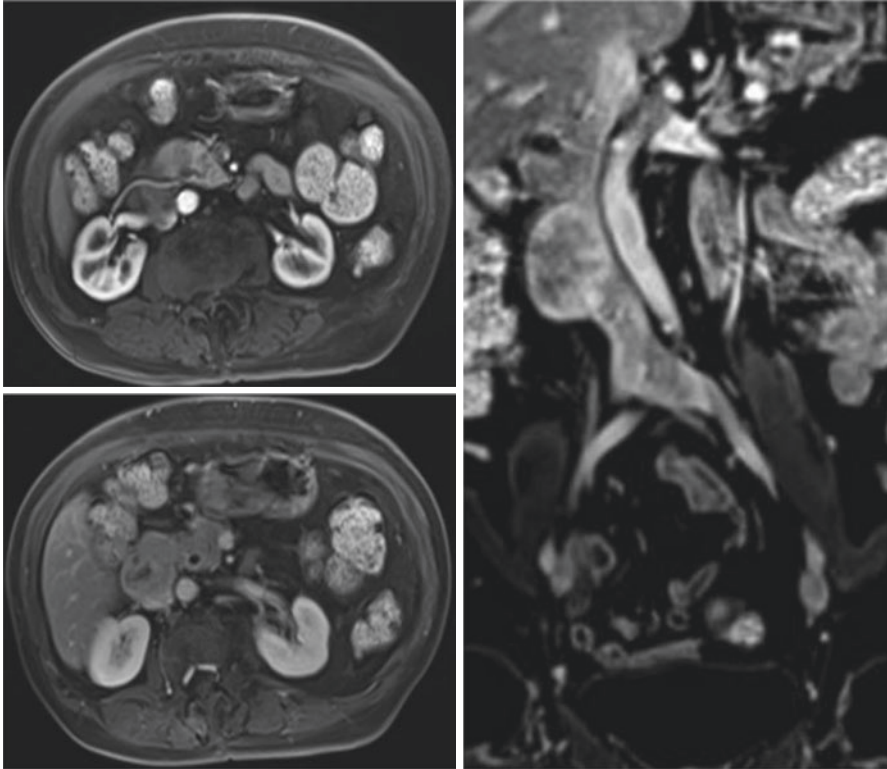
The MRI shows two solid nodular lesions on the right flank, located anterior to the inferior vena cava, causing slight compression on it, in close relationship with the duodenum. The lesions exhibit a heterogeneous signal, enhanced by contrast and restriction to diffusion, the largest measuring $5.2 \times 4.4 \times 3.8$ cm and the other measuring 3.2×2.6 cm. Note that it is difficult to determine whether the lesion is primary of the vena cava or causes compression on it; however, if the biopsy reveals the diagnosis of leiomyosarcoma, the chance of primary vascular lesion is high, as in the example
